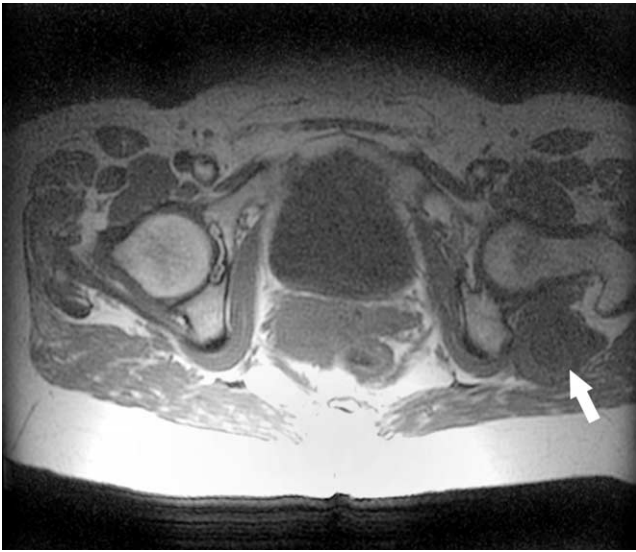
MRI showing association of L PSA aneurysm with the sciatic nerve.
